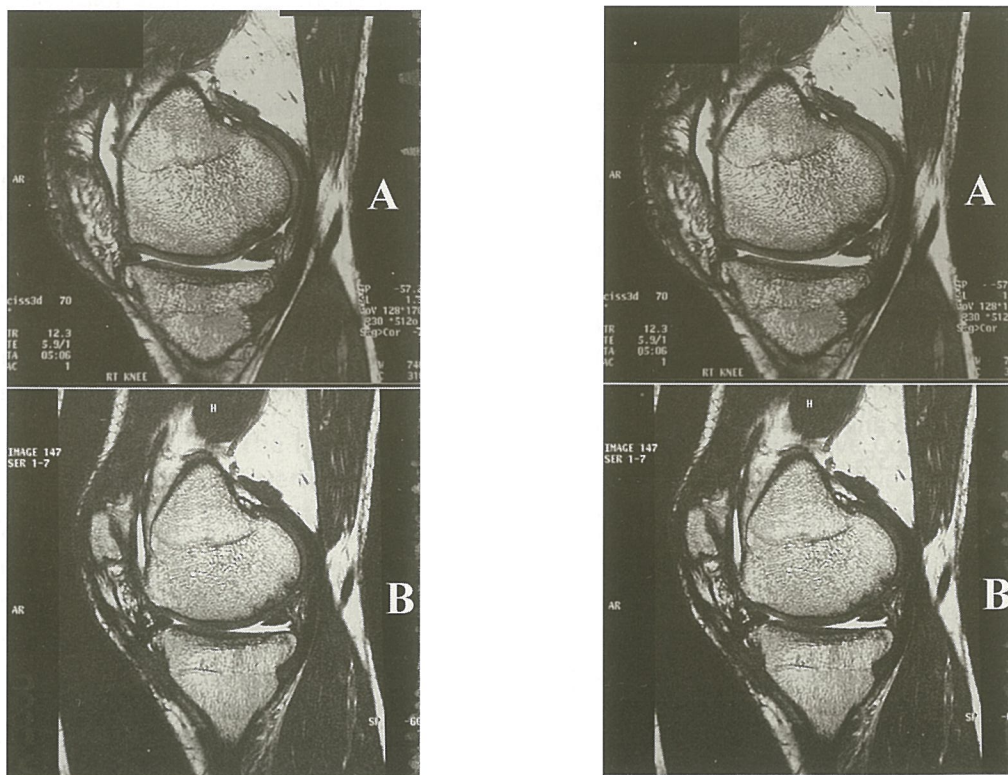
(A) Preoperative MRI showing full-thickness chondral defect in the posterior aspect of the medial femoral condyle. (B) MRI 6 months postoperatively showing complete filling of the defect with repair tissue
